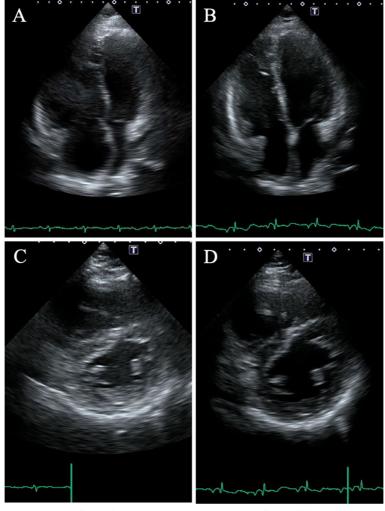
Transthoracic echocardiogram findings. A) Parasternal long-axis view. B-C) The fourchamber and parasternal long axis views show right heart dilatation and septal flattening. D) Doppler imaging demonstrated mild to moderate regurgitation of the tricuspid valve.
